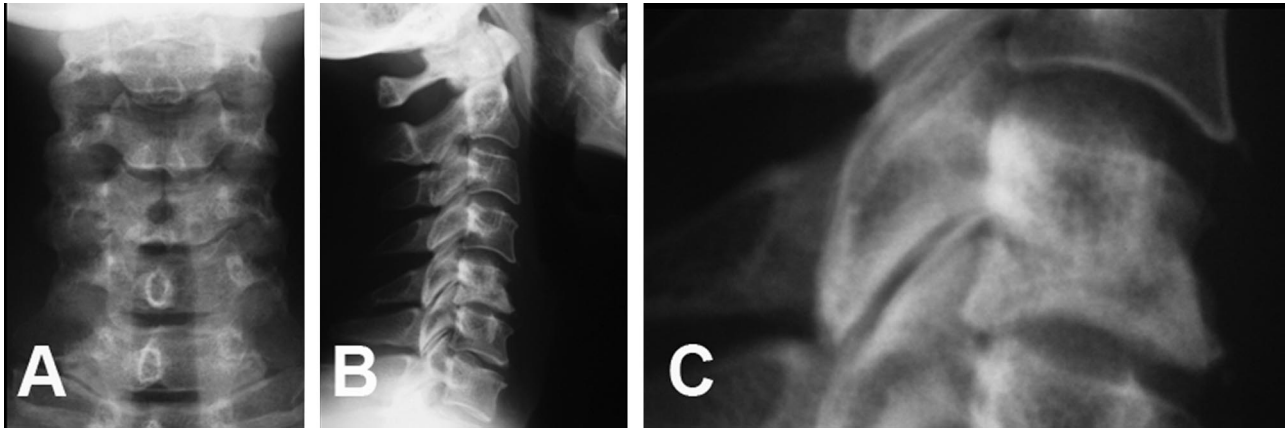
Anteroposterior (A) and lateral plain (B) radiograph of the cervical spine. There is a poorly demarcated lesion of C5 vertebral body shown on a magnified view of the lateral radiograph (C).
